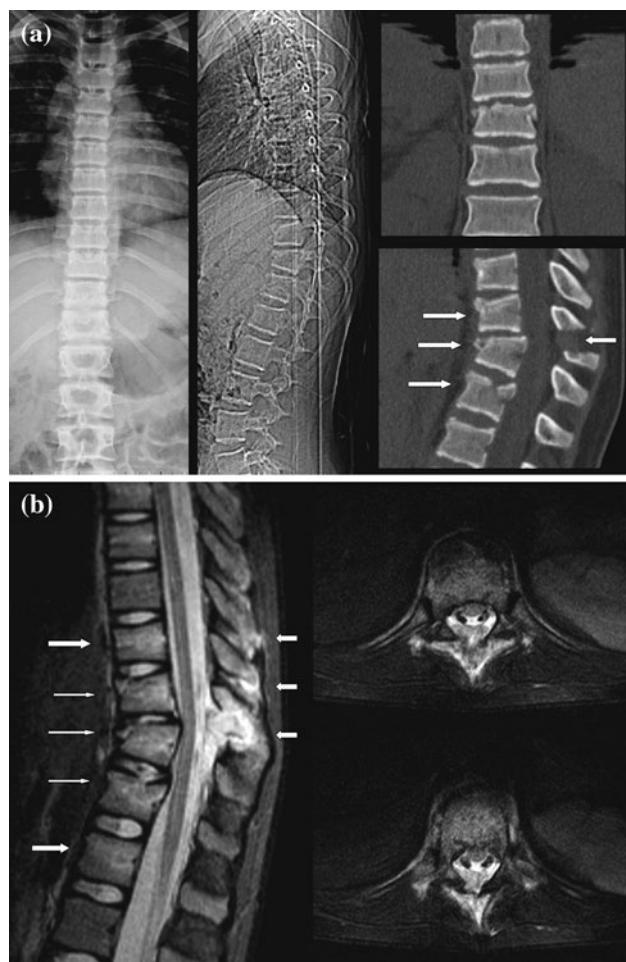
a Case 18. A female who suffered a traffic accident. Initial X-rays show a flexion distraction thoracolumbar injury. CT scan shows a three-level vertebral fracture (see arrows) at T10 (type A1), T11 (type B1) and T12 (type A3). b Case 18 after MRI. T2-w STIR sagittal images show a five-level injury: T9 an occult injury, a flexion distraction (B1 or ligamentous chance); T10 a diagnostic change from A1 to B1 due to PLC disruption; T11 demonstrates a complete rupture of the PLC (B1 injury); T12 a burst fracture with intact PLC (A3) and occult bone marrow edema at L1. T2-w FS axial images show PLC disruption at T11–T12
